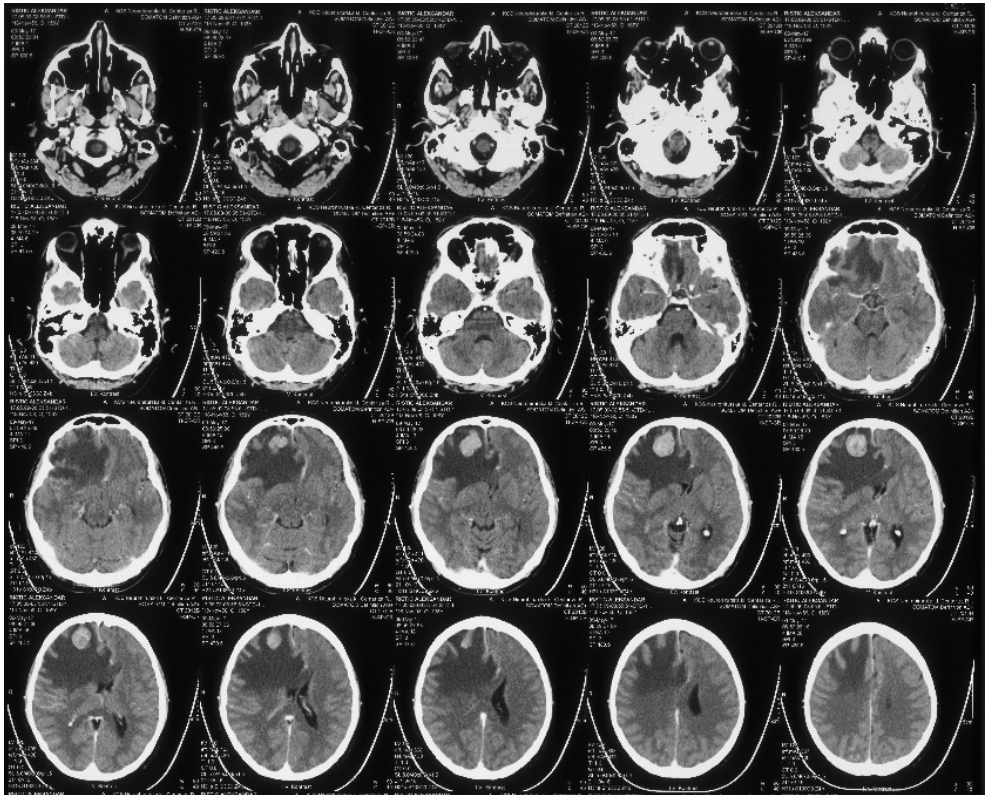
Preoperative brain CT images, Axial view
